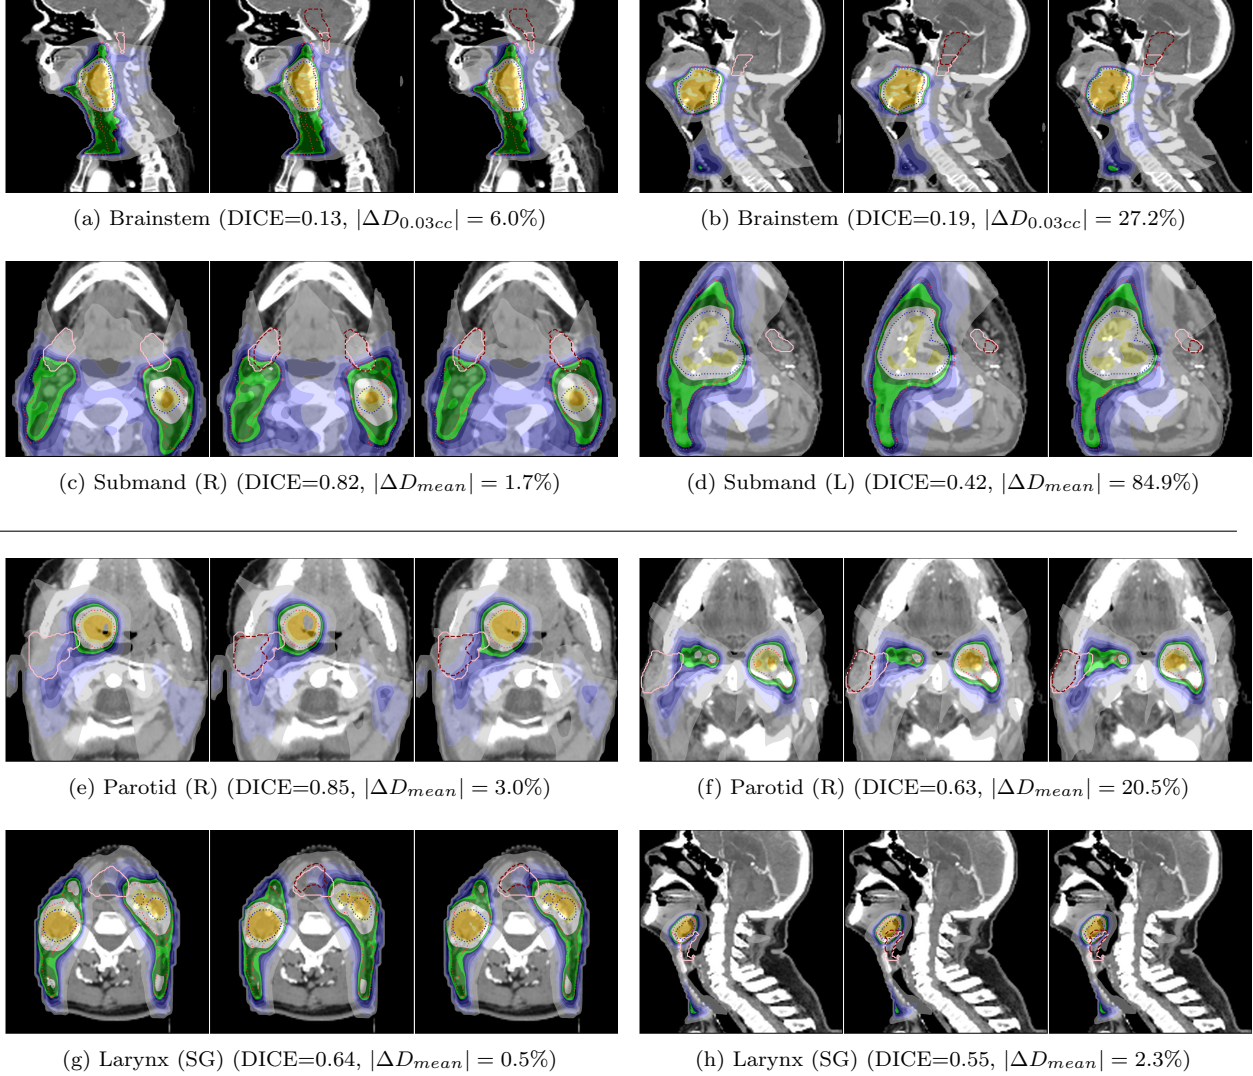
CT scans of photon (a-d) and proton (e-h) patients overlaid with a dose distribution as well as PTV (DL1) (orange), PTV (DL2) (blue), manual (pink) and automated (maroon) contours. Each example shows the P_{OG} , P_{MC} and P_{AC} plans from left to right. The dose metric in the sub-captions compares the absolute percentage difference of $P_{MC} - P_{AC}$.
